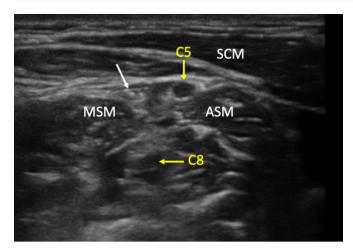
Ultrasound image of the interscalene gap (indicated by the white oblique arrow). The ventral ramus of the C5 nerve root is clearly visible anterior to the anterior scalene muscle (ASM). The ventral rami of the C6 and C7 roots are not visible in this plane. MSM, middle scalene muscle; SCM, sternocleidomastoid muscle; right side, medial.
